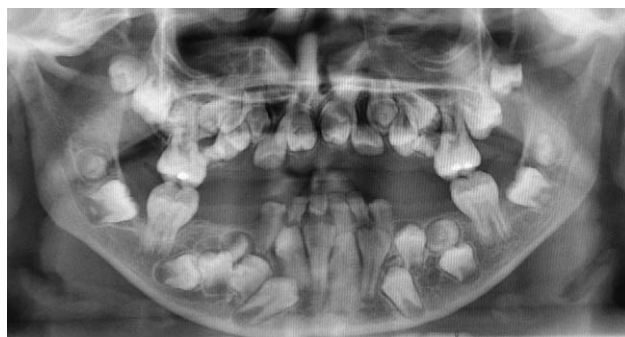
Case 3. Panoramic x-ray showing typical dental abnormalities (nonexfoliated deciduous teeth, retained permanent teeth, supernumerary teeth).
